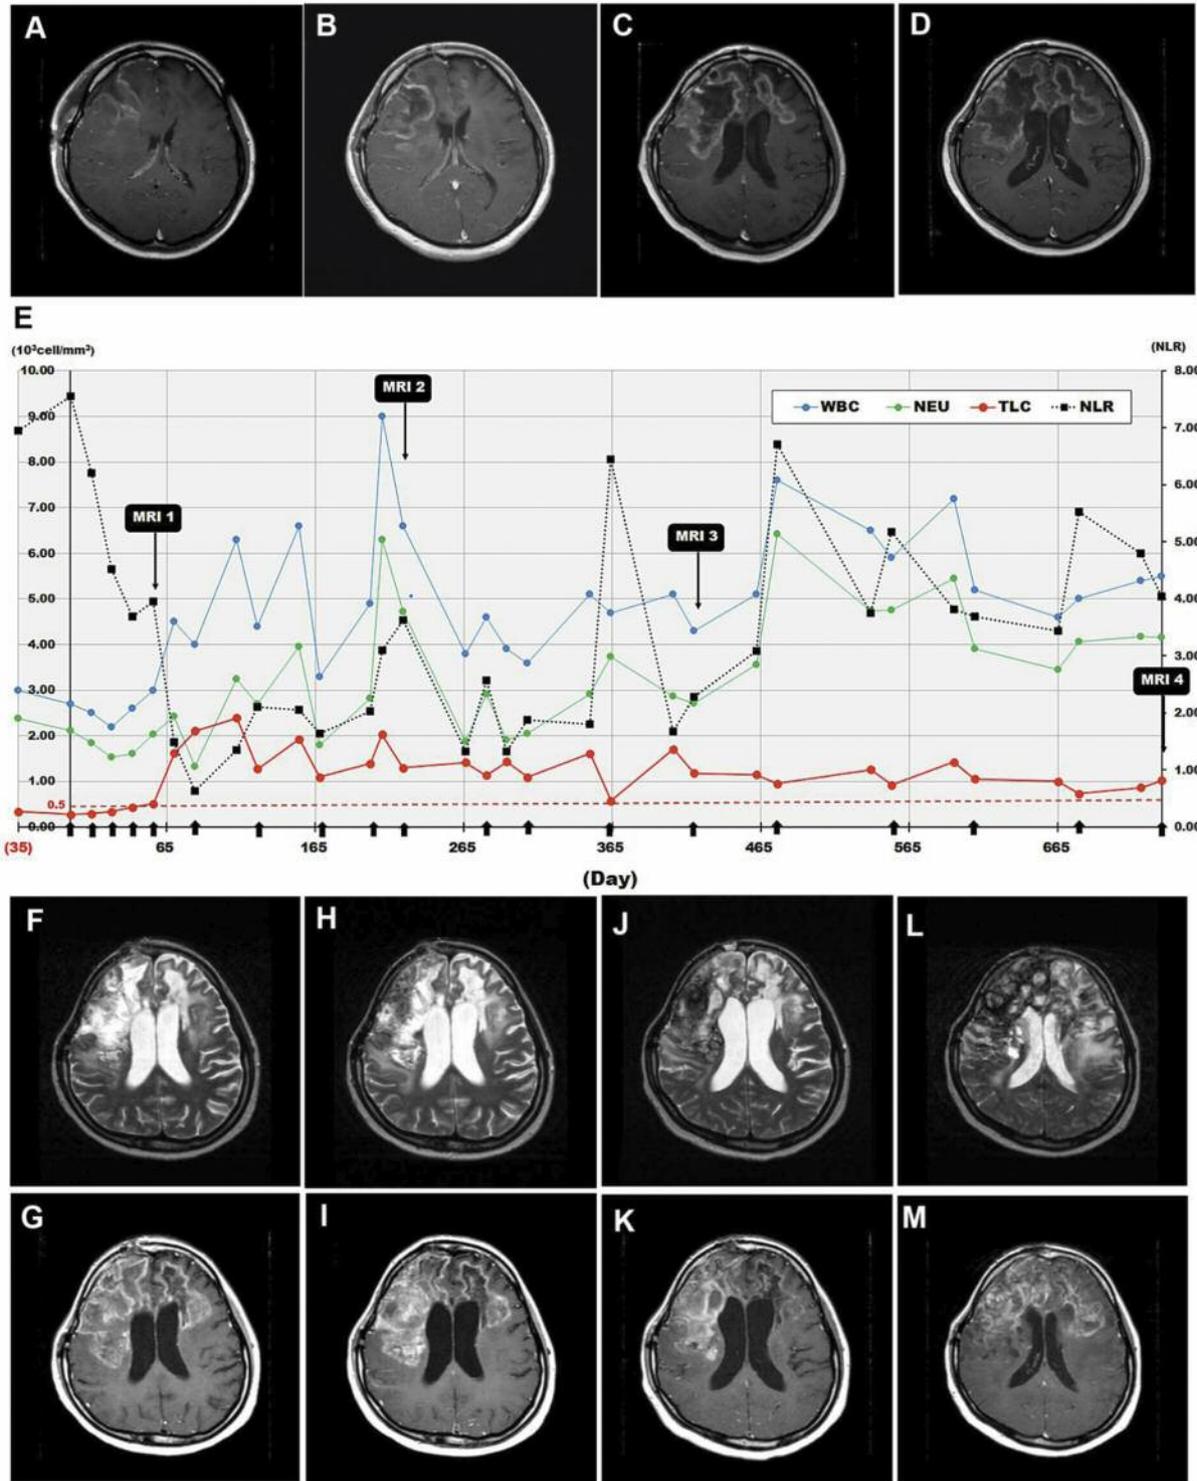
Clinical course of patient ONH-LAK20. Gd-enhanced magnetic resonance images after surgical resection (A) and initial temozolomide/irradiation (B) showed a Gd-enhanced lesion in the right frontal lobe. Five months later, Gd-enhanced lesions were identified in the bifrontal lobes (C), and showed gradual enlargement at 9 months after the initial operation (D). Line graph in (E) shows the clinical course of the  $\alpha\beta$  T-cell immunotherapy. Black arrows on the x-axis indicate the time points of  $\alpha\beta$  T-cell injection. total white blood cell (WBC) count, neutrophil (NEU) count, and total lymphocyte count (TLC) during immunotherapy are shown using the left y-axis, neutrophil/lymphocyte ratio (NLR) is shown using the right y-axis. T2-Weighted (F, H, J, and L) and Gd-enhanced (G, I, K, and M) magnetic resonance images showed that the lesions were stable at the 5th (F and G), 10th (H and I), 14th (J and K), and 19th (L and M)  $\alpha\beta$  T-cell injection.
